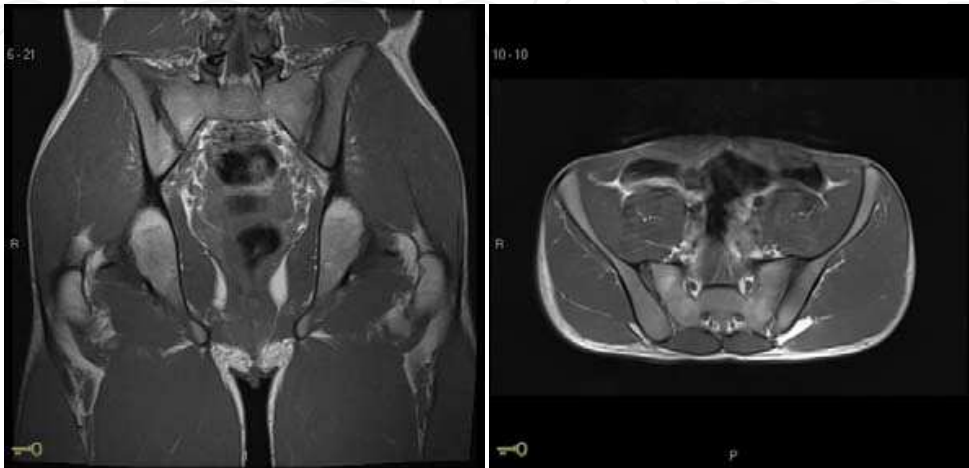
MRI images (Sagittal, left and coronal, right) showing AS in a young patient with UC
